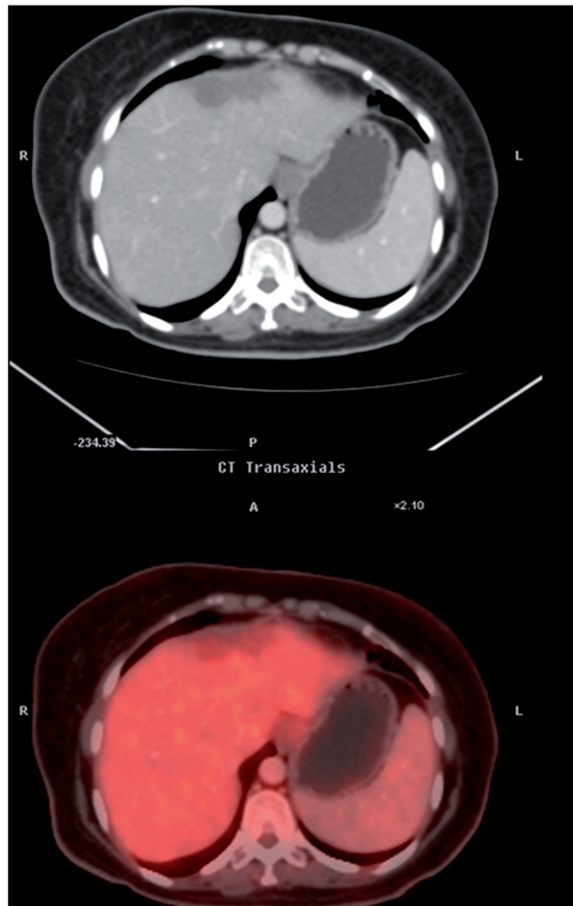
Post chemotherapy [^{18}F]FDG-PET/CT study showed that there was a persistent hypodense lesion in the liver on the CT component of the examination (upper panel); however, the FDG uptake corresponding to the liver lesion had completely resolved (lower panel) thus confirming necrotic changes.
